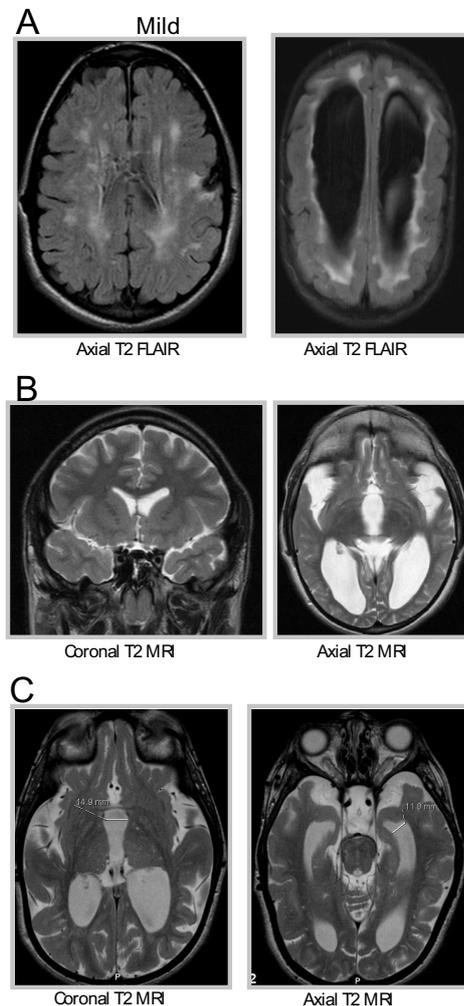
Cerebral magnetic resonance imaging (MRI) scans showing (A) white matter (WM) lesions (hyperintense regions): periventricular + subcortical WM lesions (left), diffuse WM lesions (right); (B) mild (left) and severe (right) cortical atrophy (widening of the sylvian fissure and/or hemispheric fissure); (C) ventricular enlargement. FLAIR: fluid-attenuated inversion recovery.
